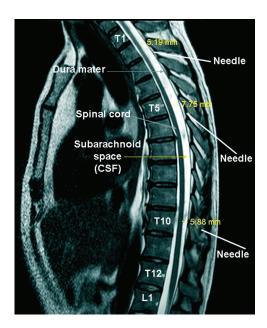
MR imaging of the thoracic column.
